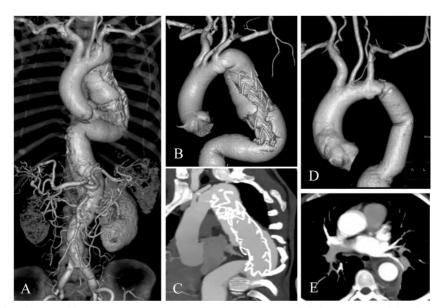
63 years old patient with aneurysmal dilatation of thoraco-abdominal aorta and Stanford type B dissection. (A-C) post EVAR CTA images. A&BVR images, C sagittal MIP images revealed Type I endoleak 6 month after EVAR. Follow up 3 month after aortic grafting (D) VR & (E) axial MIP images revealed normal appearance of the aortic graft.
